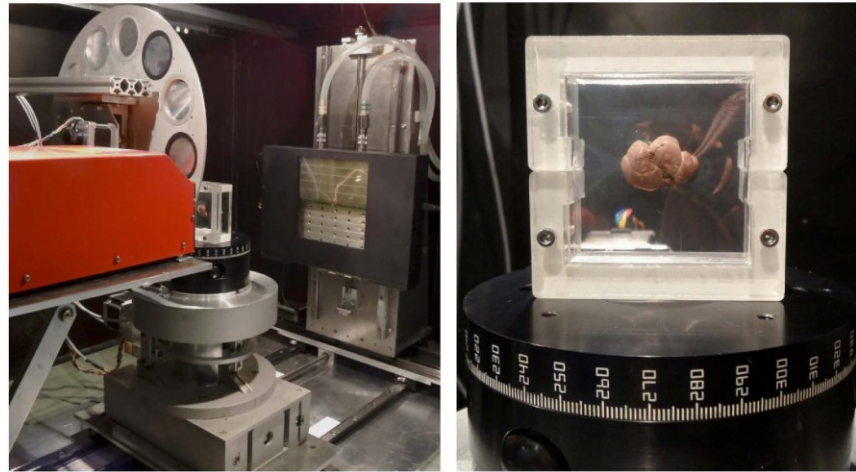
High-resolution table-top X-ray imaging setup. The system is equipped with a micro-focus X-ray tube, rotating carousel with calibrating foils, precise sample positioning stage and the large area photon counting detector with sensitive area $14.3 \times 7.15 \text{ cm}^2$ (left). Detail view of a sample holder used for 2D high-resolution X-ray imaging of soft biological samples (right).
